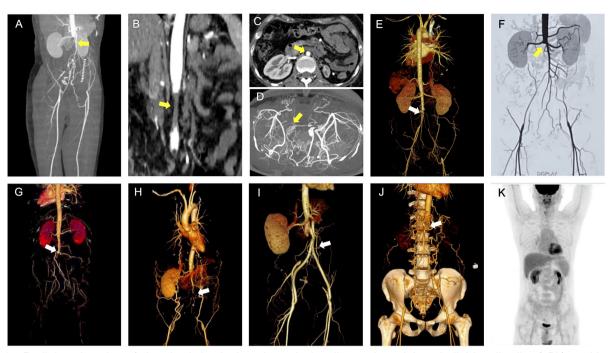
Radiology imaging of chronic abdominal aortic occlusive disease in antiphospholipid antibodies (aPL)-positive patients. Patient 1 presented complete occlusion from the infrarenal aorta, accompanied by restenosis within the graft vessel (A). Patient 2 presented a collapsed distal segment of the abdominal aorta, (B) characterised by a reduction in lumen diameter (C). Patient 3 presented a well-developed collateral circulation (D) and stenosis of the distal aorta (E). Patient 4 presented occlusion of infrarenal aorta and common iliac arteries. (F) Patient 5 showed shorter occlusion of distal aorta. (G) Patient 6 presented infrarenal aortic occlusion, inclusive of left renal artery involvment (H), and the observation of patent graft vessel (I). Patient 7 presented severe occlusion including pararenal aorta and bilateral renal artery (J), and ¹⁸F-fluorodeoxyglucose positron emission tomography-CT was normal in vessel wall (K).
